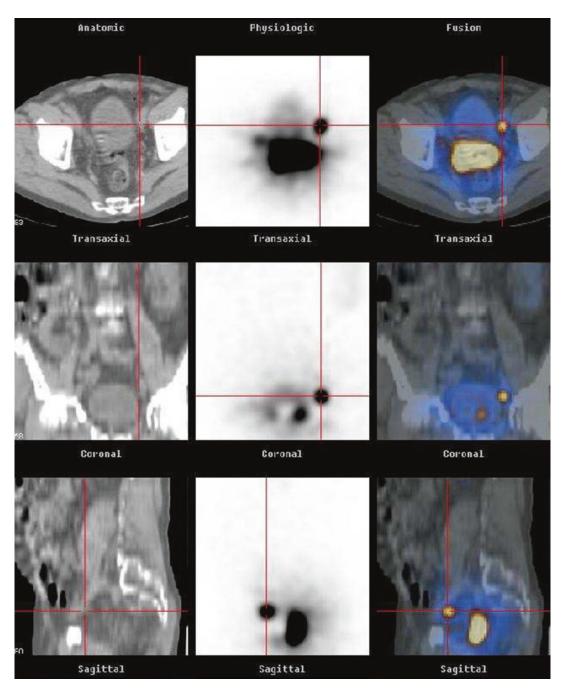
Radiological image of sentinel lymph nodes after injection of ^{99m}Tc-labeled nanocolloid into the prostate. Left column: CT scan images, middle column:
